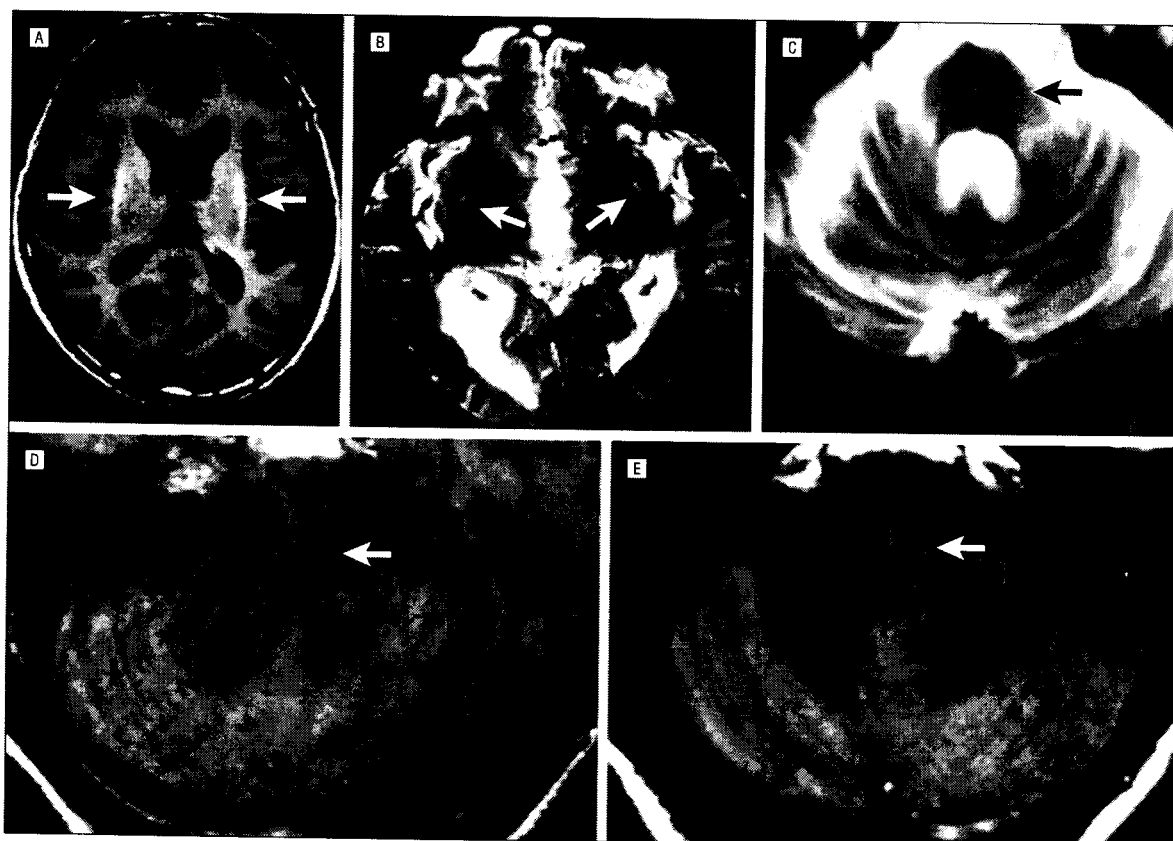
Representative brain magnetic resonance images of patients in the 4 families. A, T1-weighted image of patient II-8 in family A showing slitlike signal change at the posterolateral putaminal margin (arrows). B, T2-weighted image of patient II-2 in family B showing slitlike signal change at the posterolateral putaminal margin (arrows). C, T2-weighted image of patient II-9 in family B showing atrophy of the cerebellar vermis and pons with cross sign (arrow). D, Proton density-weighted image of patient II-5 in family C showing cross sign in the pons (arrow). E, Proton density-weighted image of patient II-7 in family D showing cross sign in the pons (arrow).
